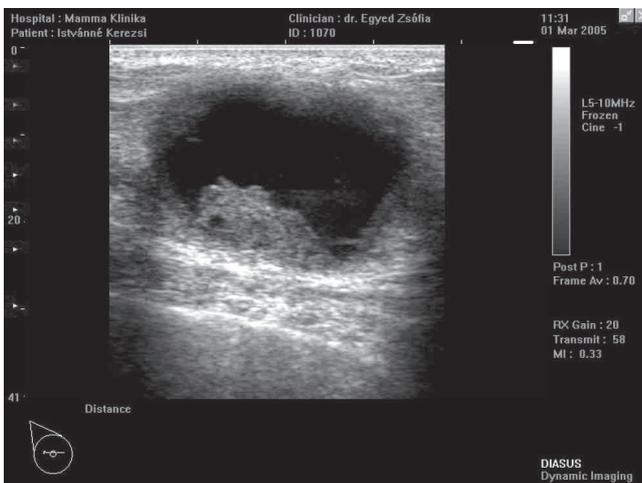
Sonogramm of an intracystic breast lesion: the irregular intraluminal mass suspect for malignancy
